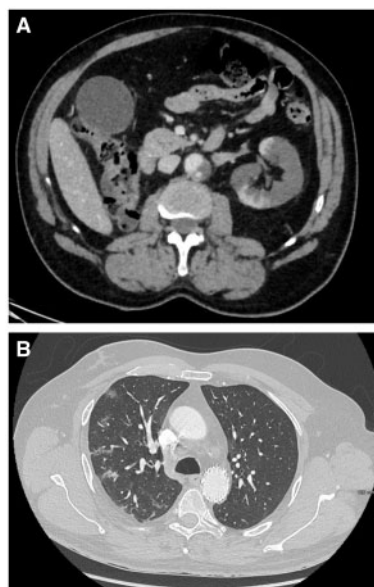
CT scan. (A) Intrastent thrombosis of the left renal artery with extensive ischaemic lesions of the renal parenchyma. (B) Bilateral, subpleural ground-glass opacities suggestive of SARS-CoV-2 pneumonia.
